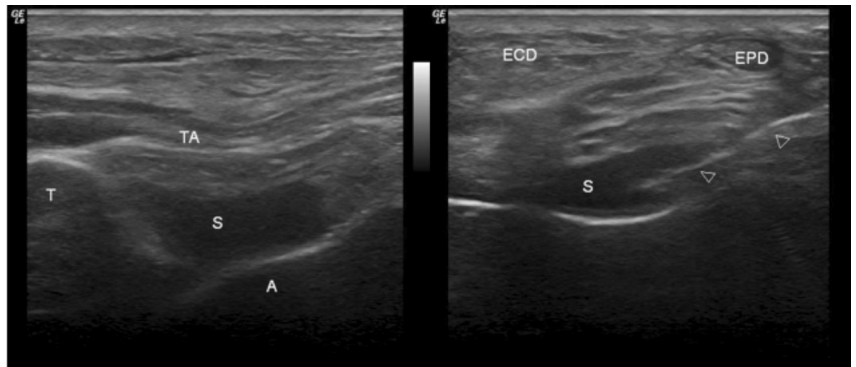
Ultrasound image of the tibi-astragalus ankle joint. Left: longitudinal view; S: abnormal synovial content, T: tibia A: astragalus, TA: tibialis anterior. Right: transversal view showing the needle reaching the synovial space (arrows); ECD: common extensor of the toes; EPD: extensor of the big toe.
